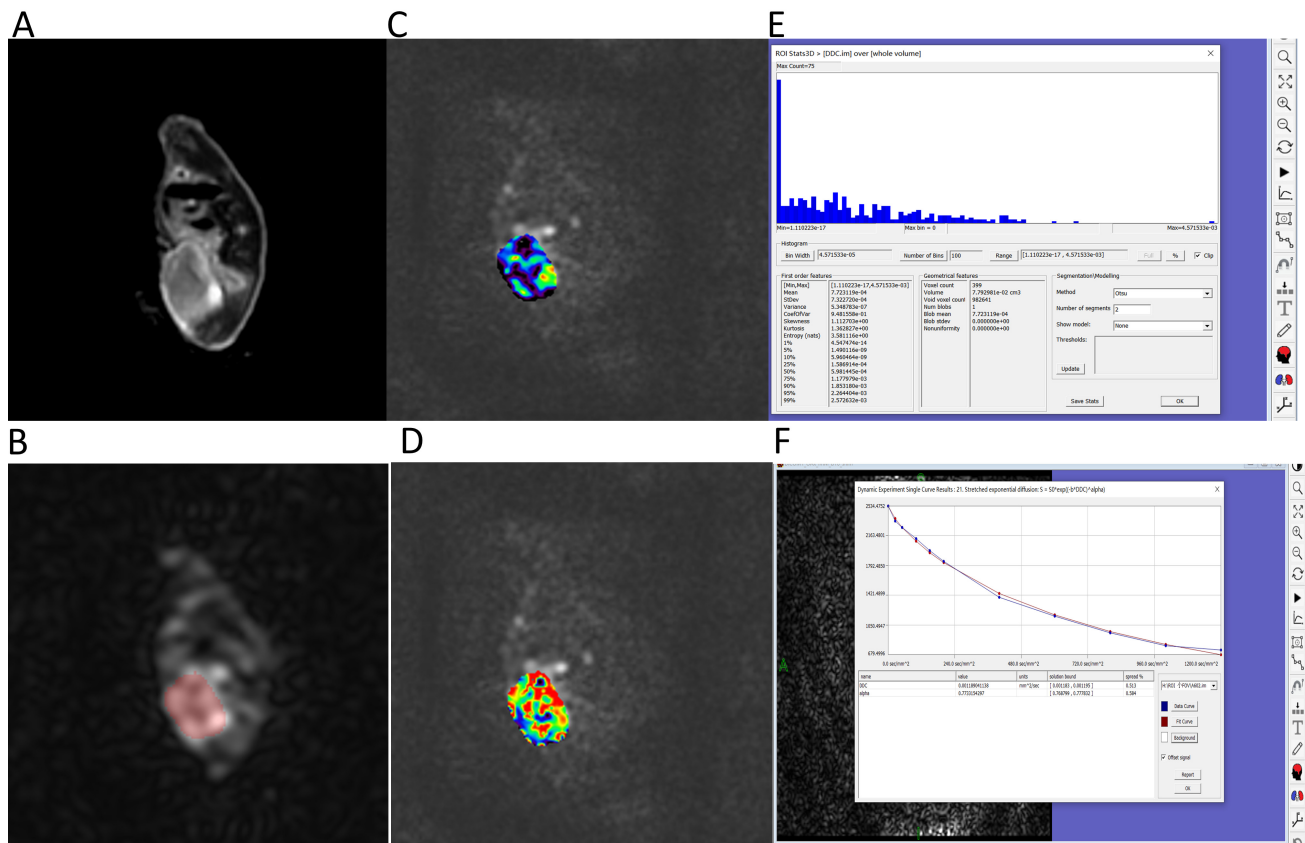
The image post-processing. (A) T2-weighted imaging. (B) Diffusion-weighted imaging (DWI) with $B = 0$, where the highlighted pink area indicates the lesion in this slice image. (C) Distribution diffusion coefficient (DDC) map of the tumor. (D) α map of the tumor. (E) Histogram analysis of stretch index model parameters. (F) Measured DDC and α values.
